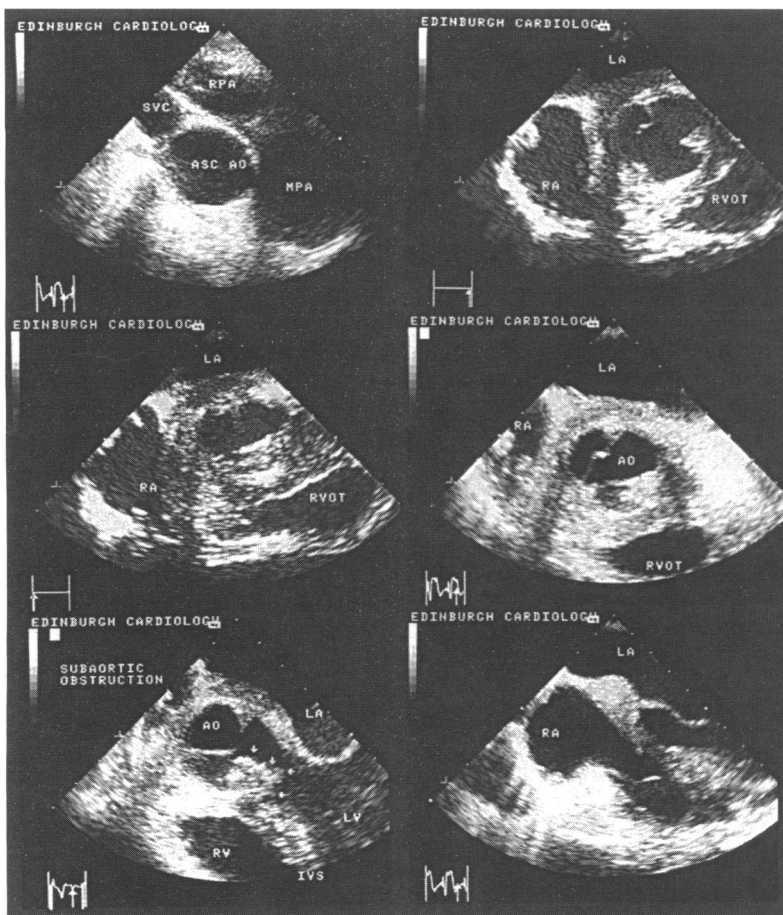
Initial pretreatment transoesophageal echocardiograms showing the features of aortic root and left ventricular outflow tract involvement in the patient described in the text. Upper left panel: transverse plane transoesophageal view at the level of the pulmonary artery. Note that walls of the ascending aorta above the aortic sinuses, the superior vena cava and the right pulmonary artery are of normal thickness. Upper right panel: the transverse plane transoesophageal probe has been advanced to the level of the upper aortic sinuses. The aortic wall thickened in a concentric manner with a ground glass appearance. The anterior wall of the right ventricular outflow tract and the right atrial medial wall are also thickened. Middle left panel: the probe has been advanced slightly further and increased thickening of the aortic root and atrial wall is seen. Middle right panel: the probe has been advanced to the level of the aortic valve, where maximal aortic root involvement is seen. Lower left panel: advancing the probe further a large mass lesion in the area of the membranous interventricular septum is seen, (arrows), which produced a pressure gradient within the outflow tract of 35–40 mm Hg as assessed by continuous wave Doppler. Lower right panel: retraction of the probe and angulation towards the atrial septum demonstrated involvement by Wegener's tissue of the anterior portion of the interatrial septum. The tissue of the foramen ovale and superior rim of the atrial septum was normal in thickness and appearance. SVC, superior vena cava; RPA, right pulmonary artery; ASC AO, ascending aorta; MPA, main pulmonary artery; LA, left atrium; RA, right atrium; RVOT, right ventricular outflow tract; AO, aorta; IVS, interventricular septum; RV, right ventricle; LV, left ventricle.
